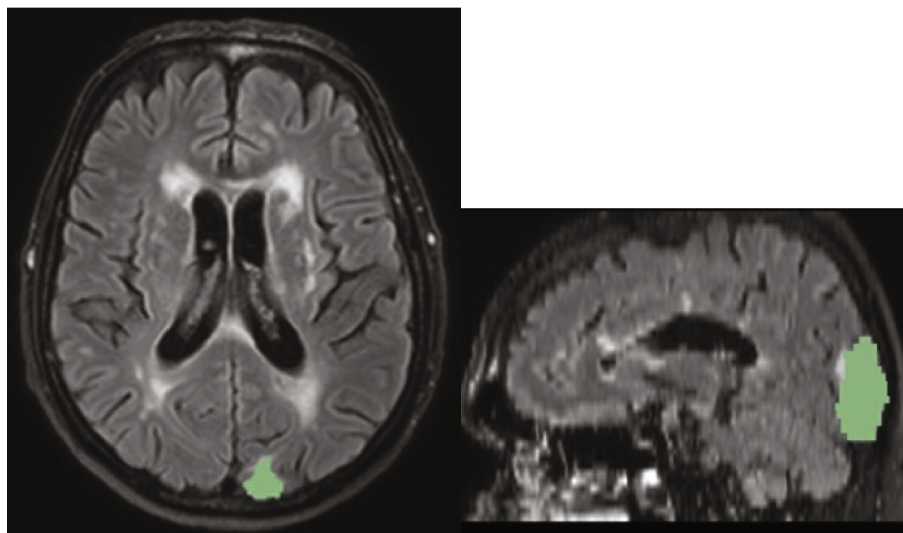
2D FLAIR volumetric mapping of acute infarct in the left occipital lobe in a 62-year-old male with an infarct volume of 37 cc, coloured with green overlay.
